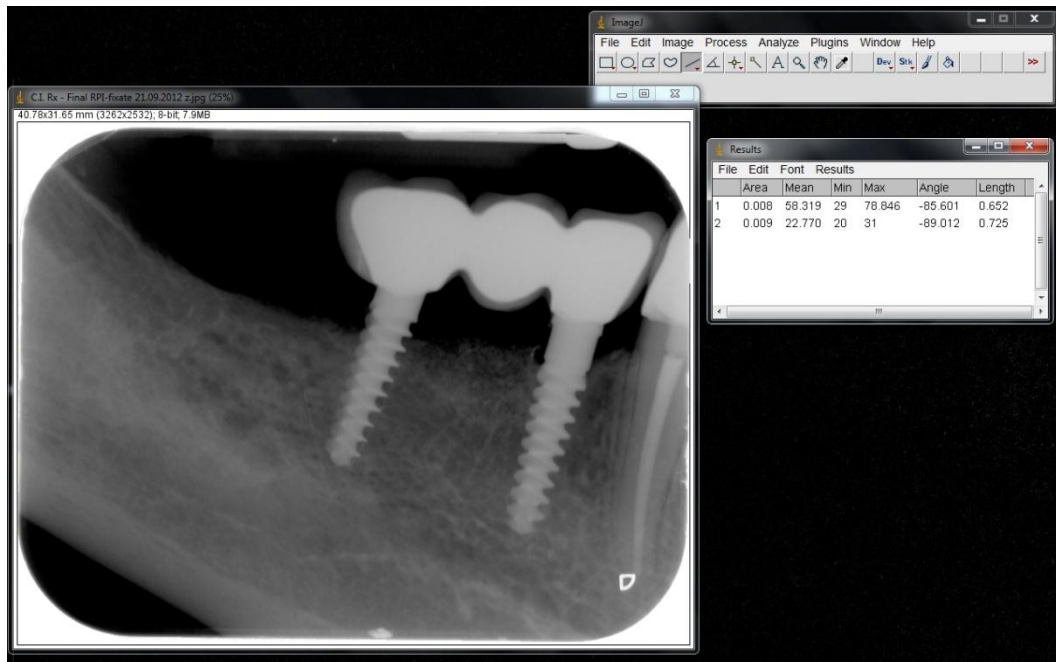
X-ray analyzes in Image J 1.46r software and its results in an xls database
